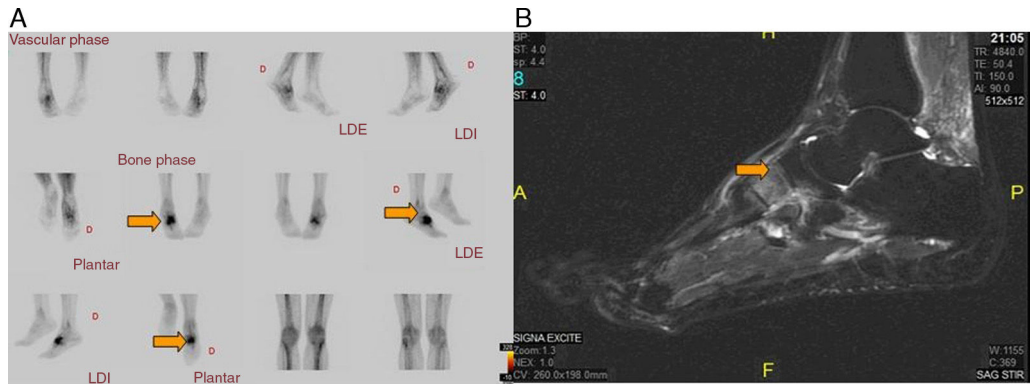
(A) Bone scintigraphy using ^{99m}Tc , which reveals a severe lesion in the naviculocuneiform region of right tarsus. (B) Sagittal magnetic resonance imaging in short tau inversion recovery (STIR) sequences with an increased signal intensity. More evident at the intermediate cuneiform level and right lateral region.
